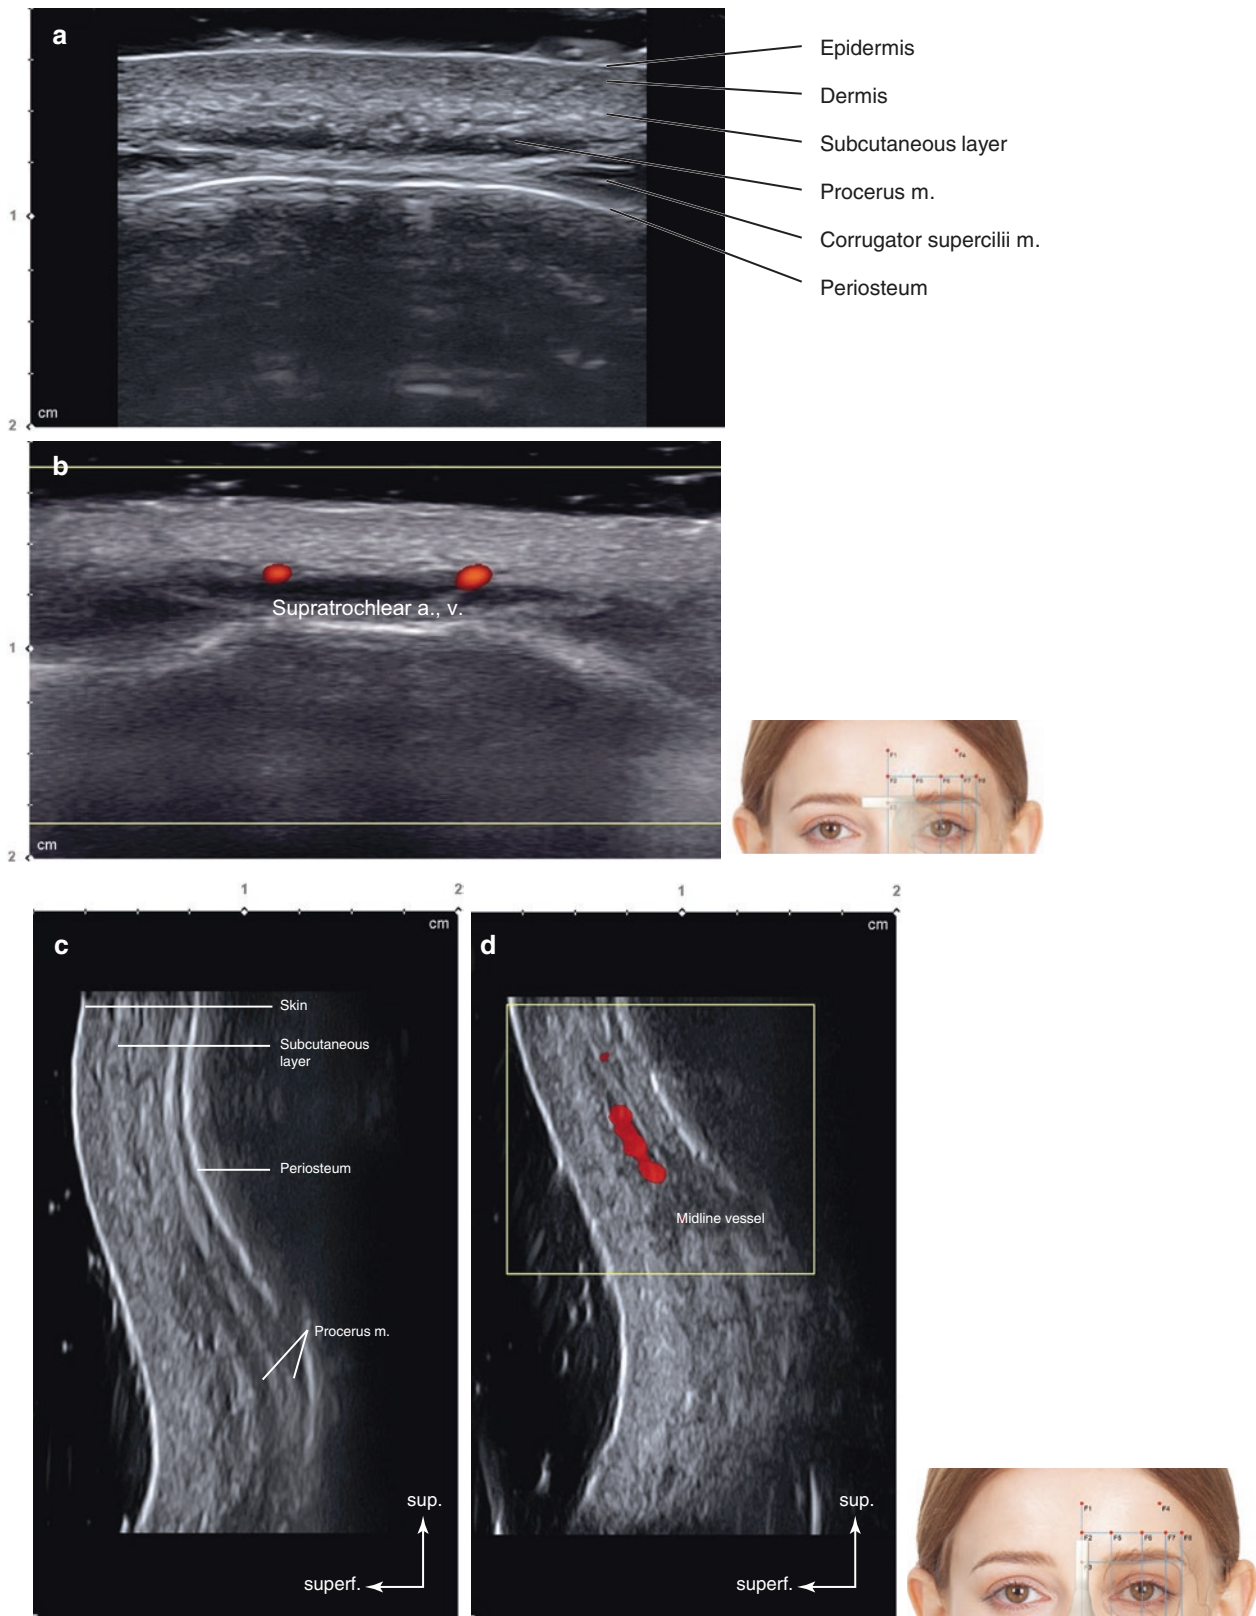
Ultrasonography on the glabella (F3). (a) B mode (transverse view, 15 MHz by linear transducer), (b) Doppler mode (transverse view, 15 MHz by linear transducer), (c) B mode (sagittal view, 15 MHz by linear transducer), and (d) Doppler mode (sagittal view, 15 MHz by linear transducer). (Published with kind permission of © Hee-Jin Kim 2020. All Rights Reserved)
